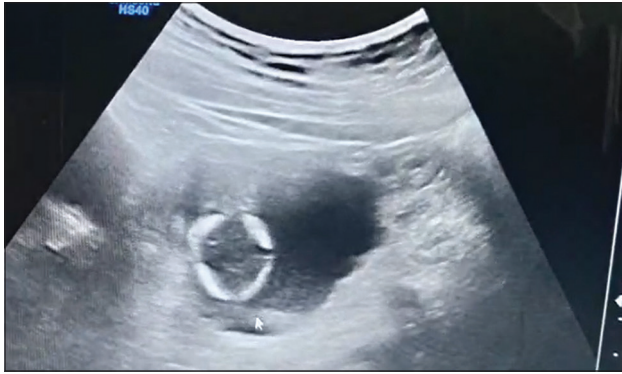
Ultrasound showing an impacted fetal head
